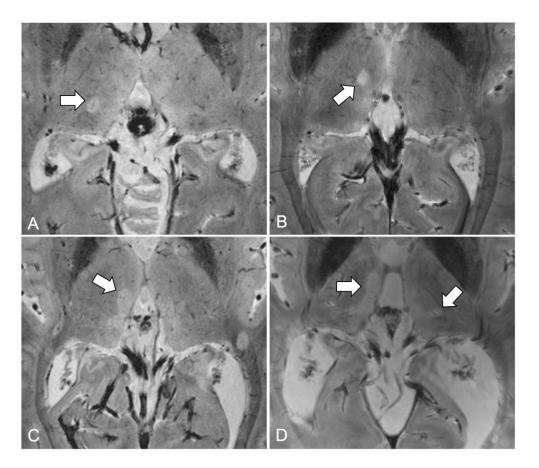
Examples of thalamic multiple sclerosis lesions on 7 Tesla T_2 *-weighted MRI images. (A) Ovoid lesion with central venule on right thalamus; (B) Ovoid lesion without central venule on right thalamus; (C) Periventricular lesion on third ventricle; (D) Multiple thalamic lesions including periventricular and ovoid lesions.
